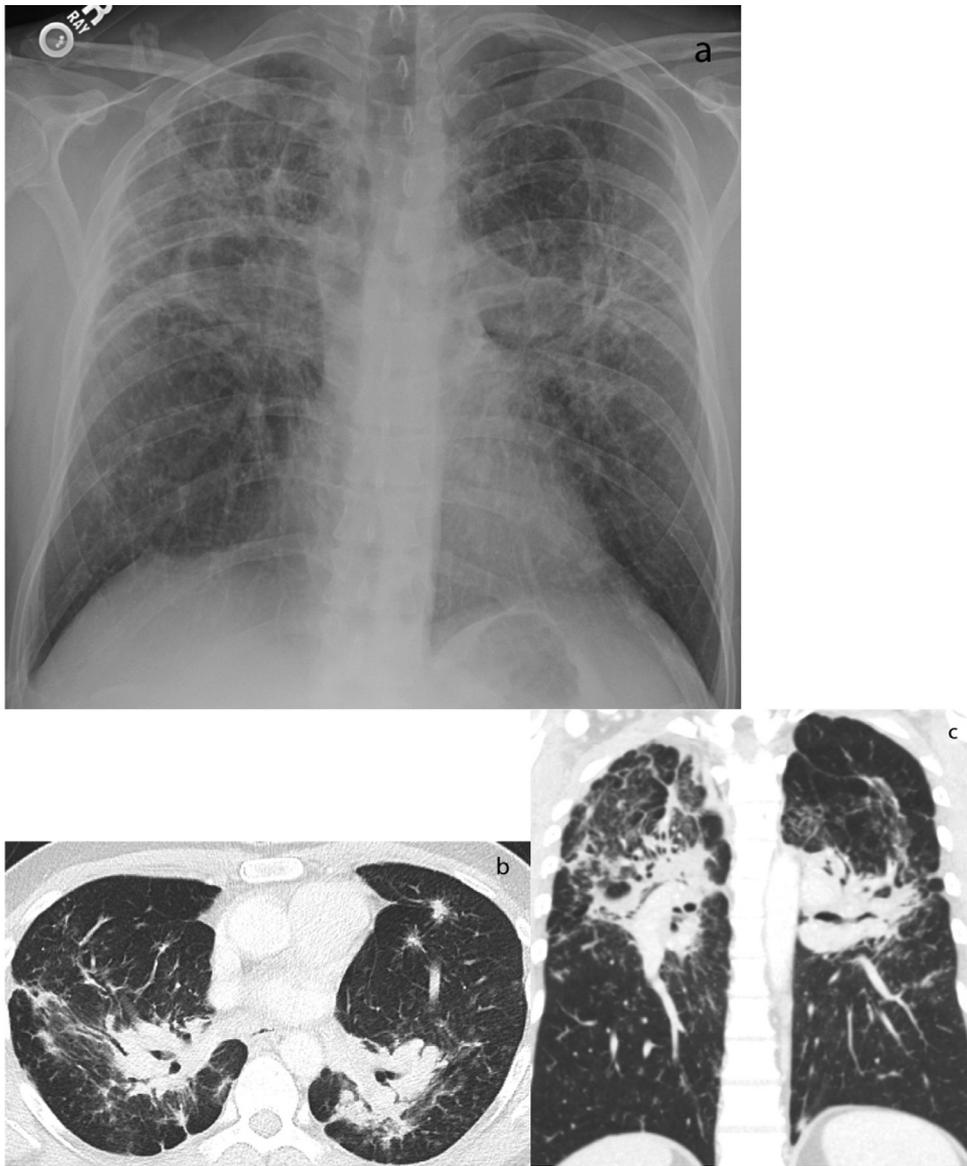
(a-c) Chest radiograph (a) and CT (b, c) showing upper lung predominant fibrosis and architectural distortion. CT, computed tomography.
